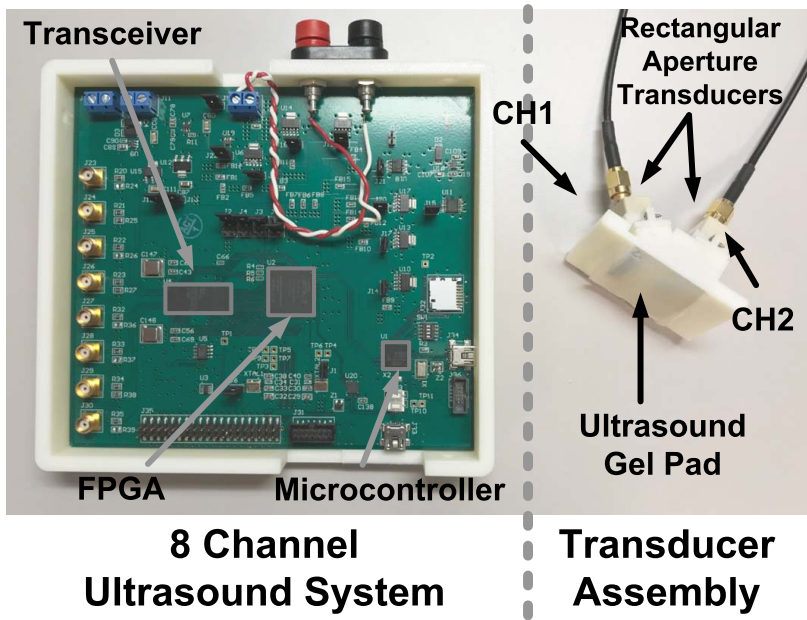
Prototype ultrasound scanner system used in the Valsalva maneuver study and NEWEST study with the second probe design [70].
